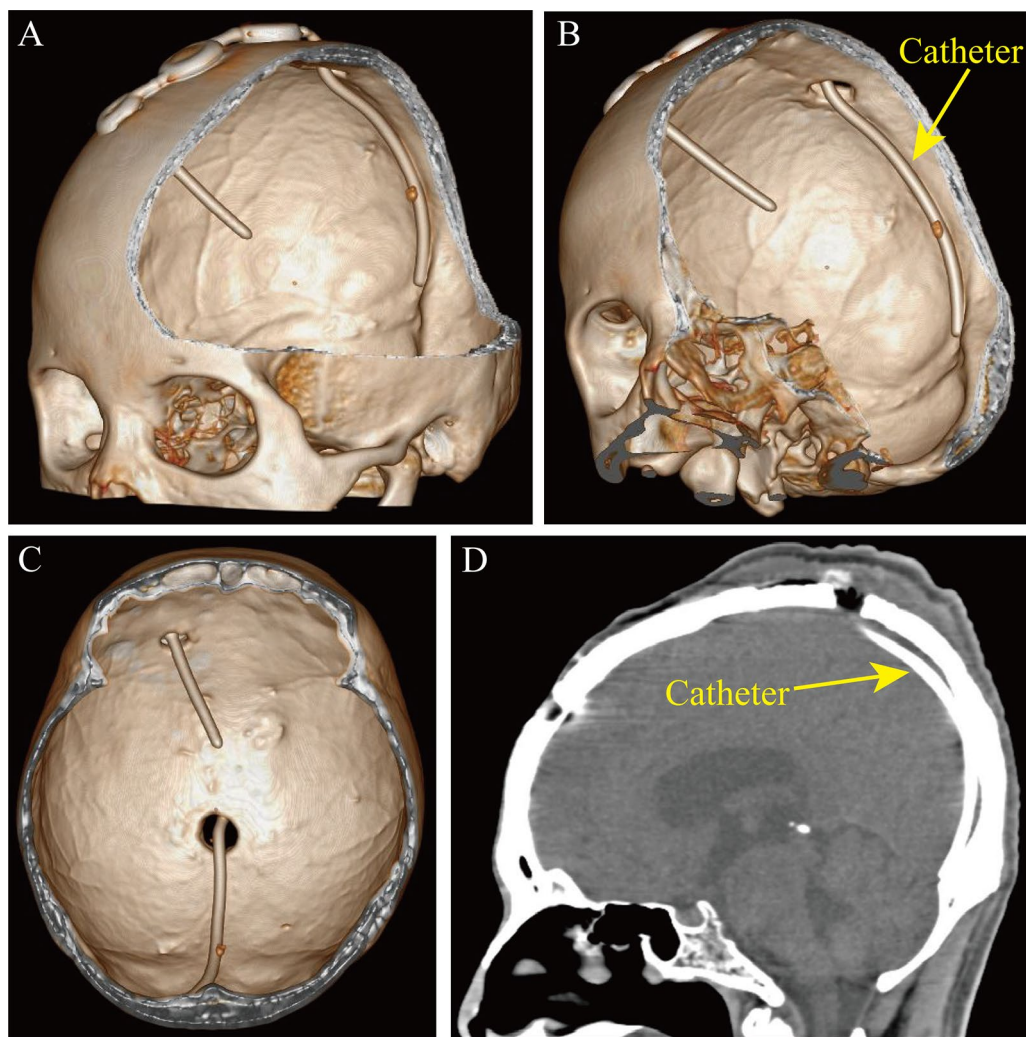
The implantation of the VSS shunt system in the cranial venous sinus was scanned using 3D CT with a 1.0 mm-slice thickness. The volume rendering technique was utilized to generate dimensional images in three orientations. The data obtained were treated in an image workstation for 3D reconstruction to show the position of the VSS shunt system (a–c). The entire length of the catheter was measured in the sagittal plane, and the end of the distal catheter had not reached the confluence of sinuses and was concurrently below the ventricular end of the catheter on the horizontal plane (d)
